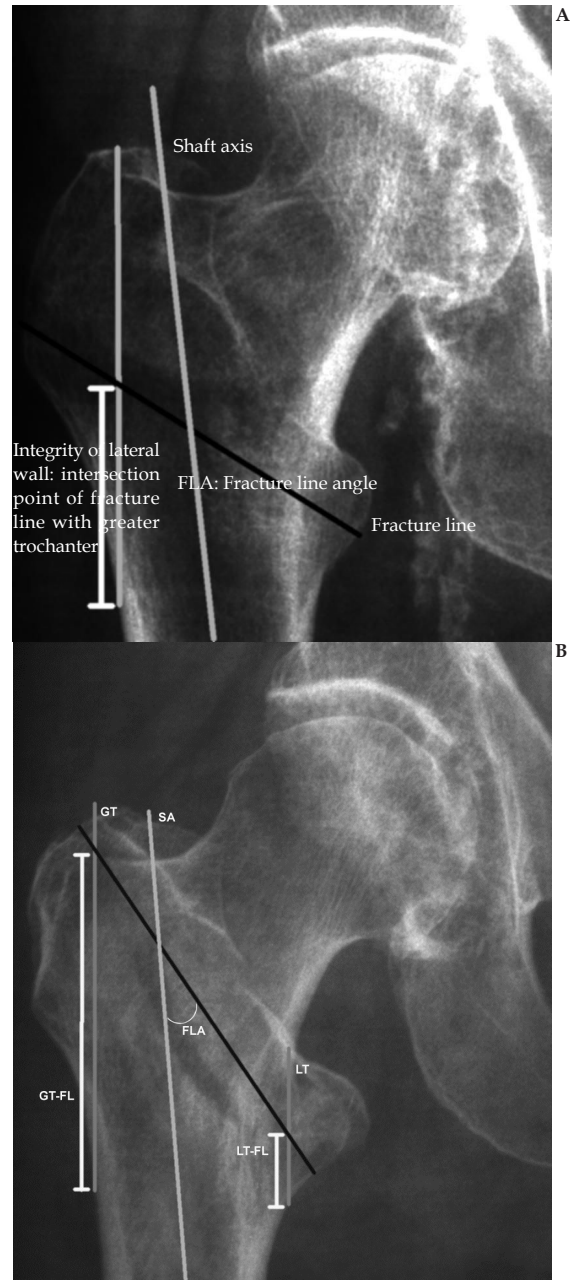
Measurements made using Image J™ on preoperative radiographs. Example of measurements made using Image J™ on preoperative radiographs, Key: FL: fracture line, GT and LT: lines that represent the length of the greater and lesser trochanter, GT-FL length of GT to the point where it intersects with the fracture line (FL), (LT-FL: length of the lesser trochanter line to the point where it intersects with line the fracture line was not included in this study).
